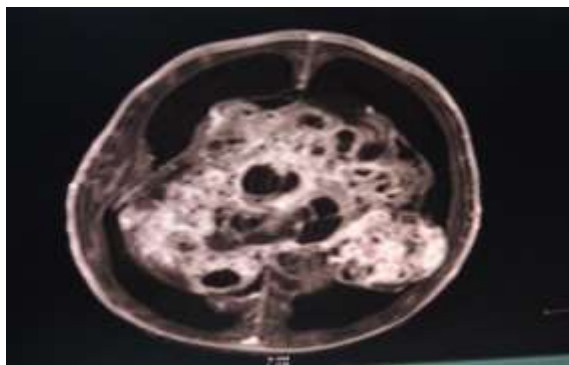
Magnetic resonance images showed a large solid cystic lesion with hemorrhagic component in bilateral hemisphere posterior to third ventricle and in posterior fossa with approximate size 82*11*102 mm compressing over bilateral lateral and third ventricles with their dilatation
